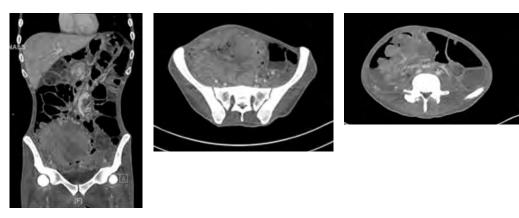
CT-scan of a 10.6 cm Anteroposterior x 14.9 cm transverse x 14 cm craniocaudal enhancing soft tissue mass centered within the right lower quadrant and pelvis.
